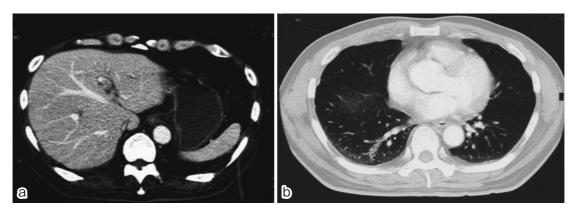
a: Abdominal CT: Abdominal CT does not show ascetic fluid or hepatic metastasis. b: Chest CT: Chest CT does not show lung metastasis.
